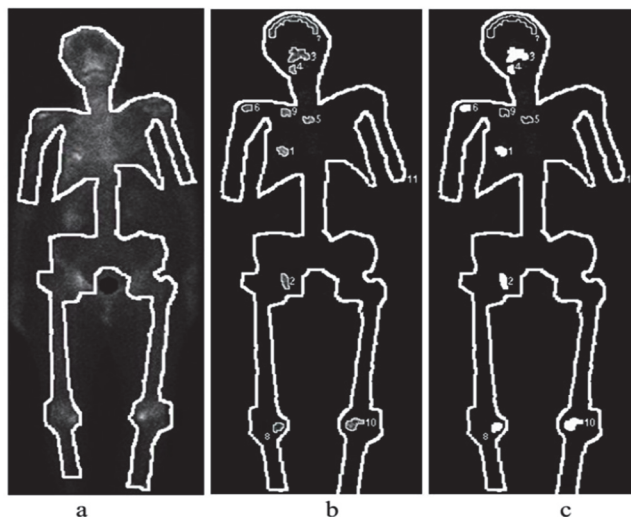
Planar bone scintigrams of patient *N*:
